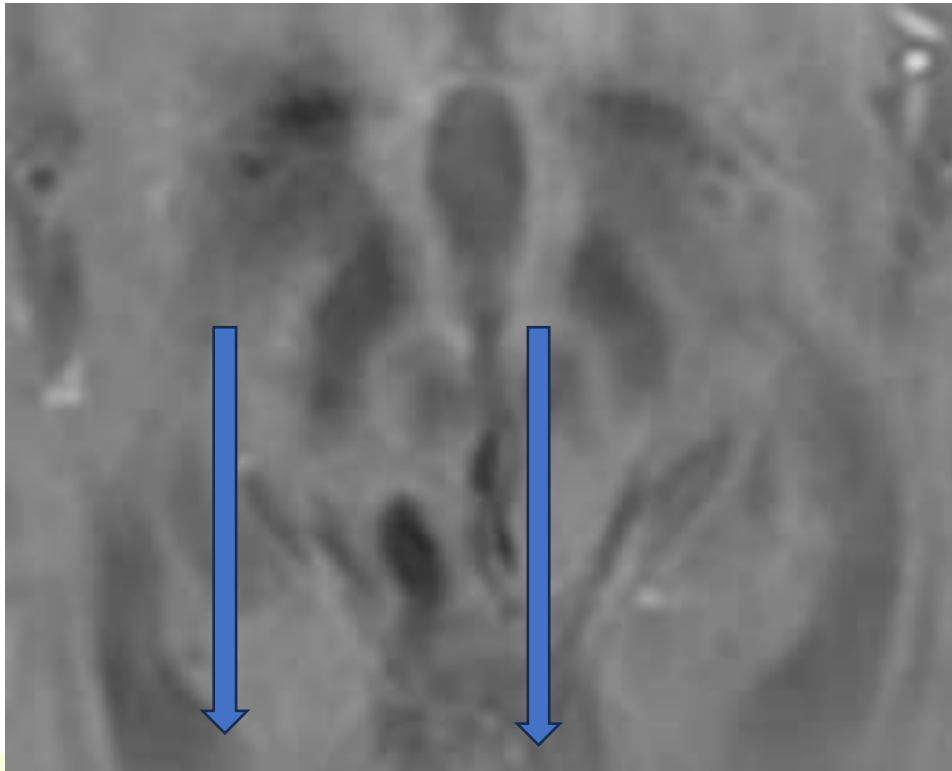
A 64 years female patient presented with resting tremors, postural instability MRI Axial SWI image sequence showing bilateral loss of swallow tail sign diagnosed as IPD.
